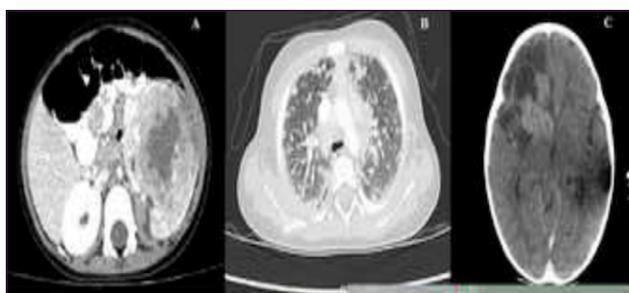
A: Computed tomography showed a heterogeneous mass (6x7x8 cm), centrally hypodense, cystic and necrotic areas in the lower middle pole of the left kidney B: Computed tomography showed multiple nodular metastatic lesions and infiltration in the bilateral lung C: Computed tomography of brain showed a mass (2x3 cm) in the pineal region and a solid mass (2x2 cm) in the left frontal lobe
